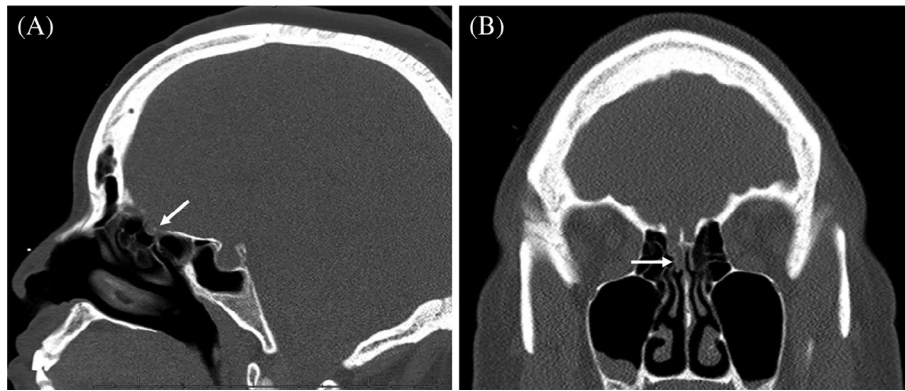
Computed tomography scan without contrast in the (A) sagittal plane and (B) coronal plane demonstrating the defect in the right cribriform plate (arrows).
